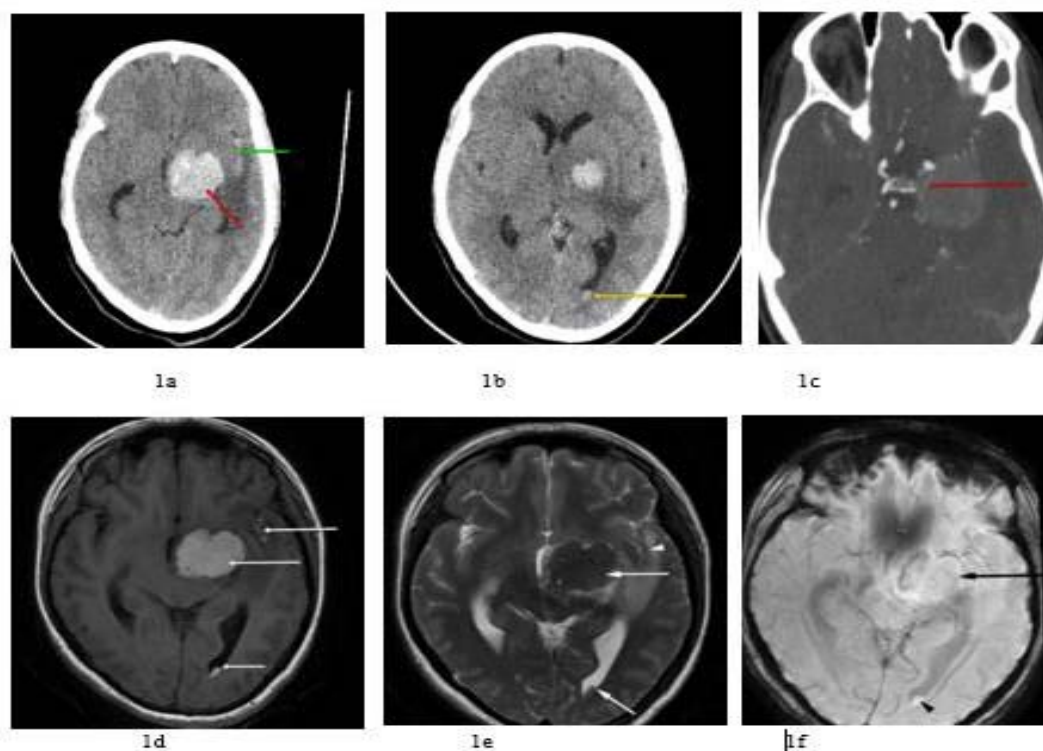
Figure a: Axial NCCT showing an extra-axial hyperdense lesion (red arrow) and hyperdensity along the left sylvian fissure (Green arrow). Figure 1b: Intraventricular hyperdensity in occipital horn of left lateral ventricle (Yellow arrow). Figure 1c: Axial CT Angiography image shows a thin feeder vessel (Red arrow) directly arising from Left MCA, traversing along and directly supplying the lesion. Figure 1d: Axial T1 weighted image shows hyperintense lesions (White arrows). Figure 1e: T2 weighted axial images show hypointense lesions (White arrows) and along sylvian fissure (Arrow head). Figure 1f: SWAN sequence shows no blooming in the extra axial lesion (Black arrow) and along the lesion in occipital horn (Black arrow head).
